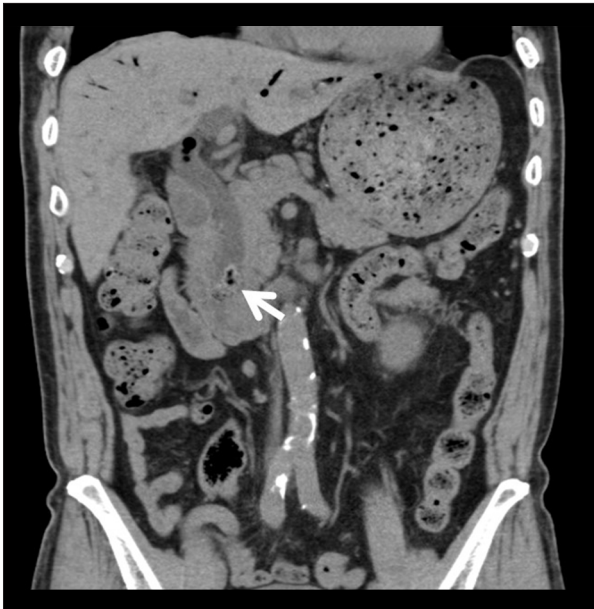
Abdominal CT reveals a mass of diameter 24 mm, which is suspected to be choledocholith (arrow), in the duodenal end of the common bile duct.
